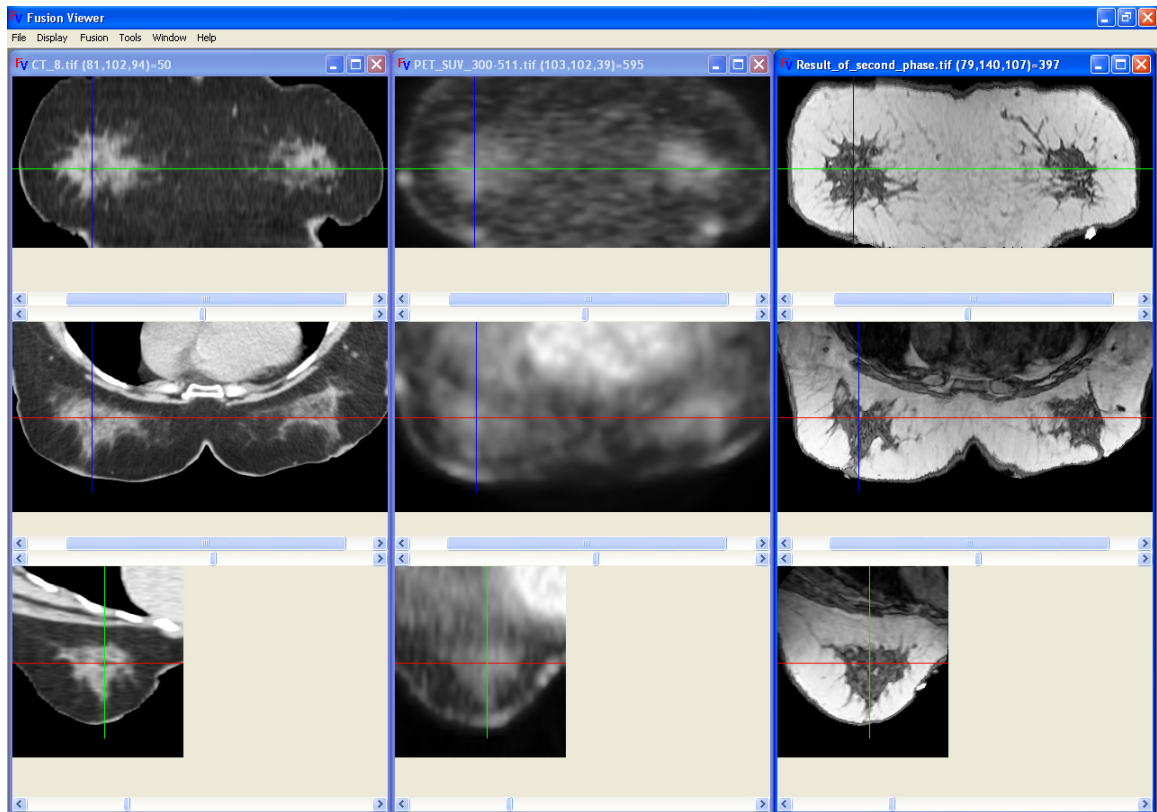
Volumes displayed as orthogonal cross-sections. The top images are coronal slices, the middle are axial slices, and the bottom are sagittal slices. From left to right a CT data set, a PET data set, and a MRI data set are shown.
